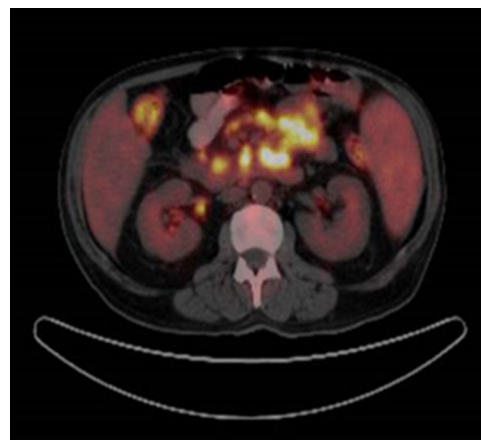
Mesenteric adenopathy growth in the PET-CT.
